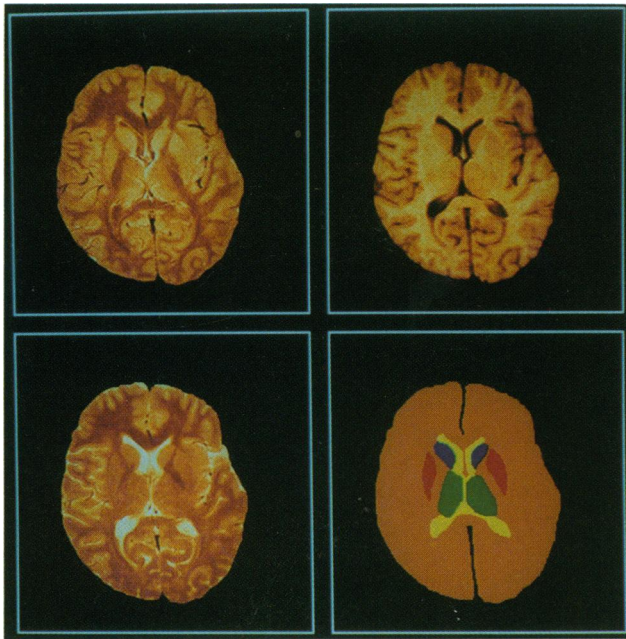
Textbook components: spin-density (Upper Left), t1-weighted (Upper Right), and t2-weighted (Lower Left) MR images and a hand segmentation (Lower Right).
